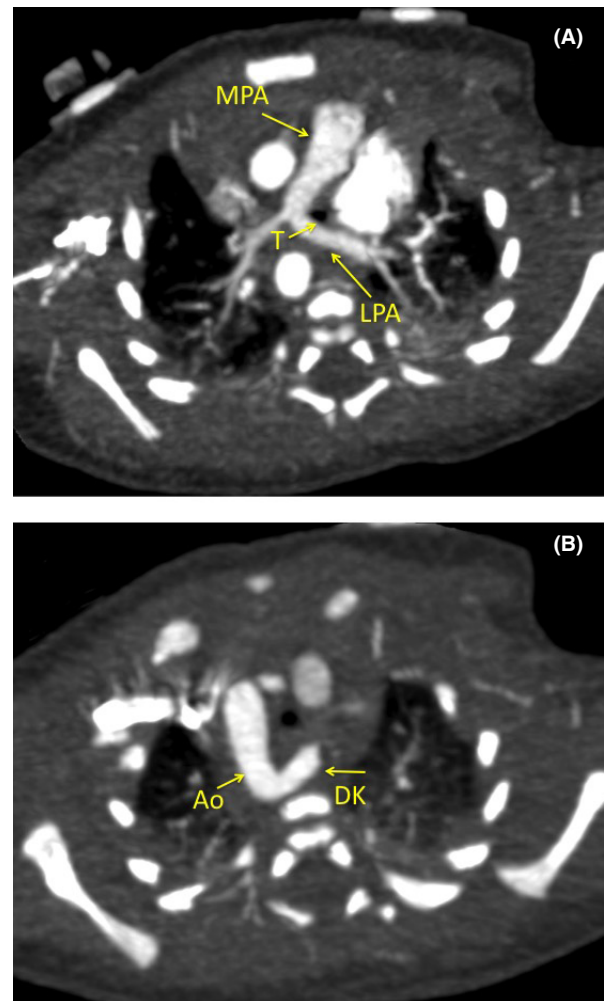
(A) Postnatal CT axial view showing the left pulmonary artery (LPA) sling coursing posterior to the trachea (T) and (B) right aortic arch (Ao) with diverticulum of Kommerell (DK).
